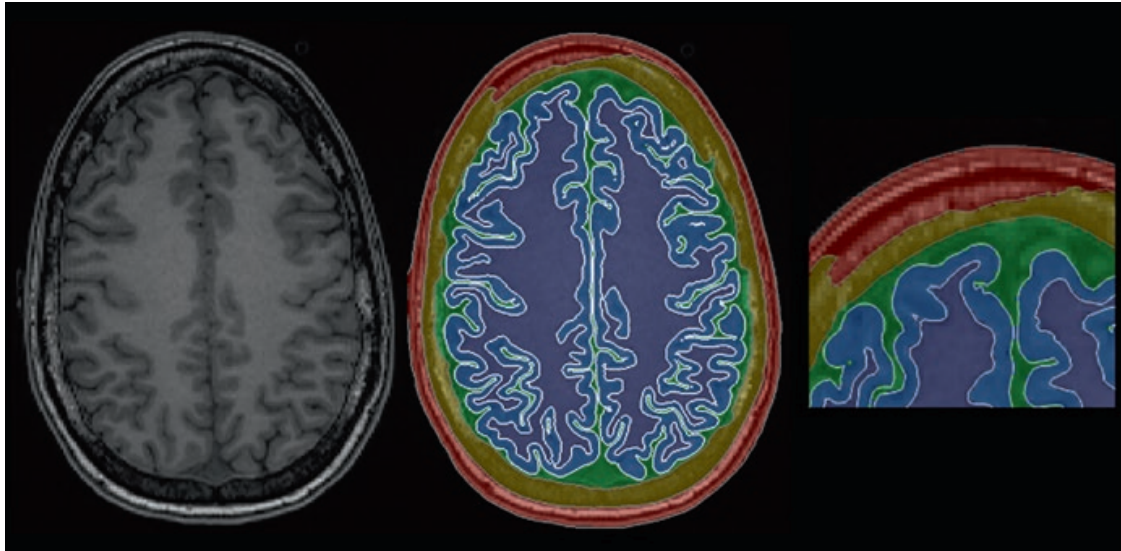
Example of a segmentation error after headreco processing. The spongy bone is erroneously labelled as skin. This example emphasizes the need for fat-suppression when using only a T1-weighted scan
